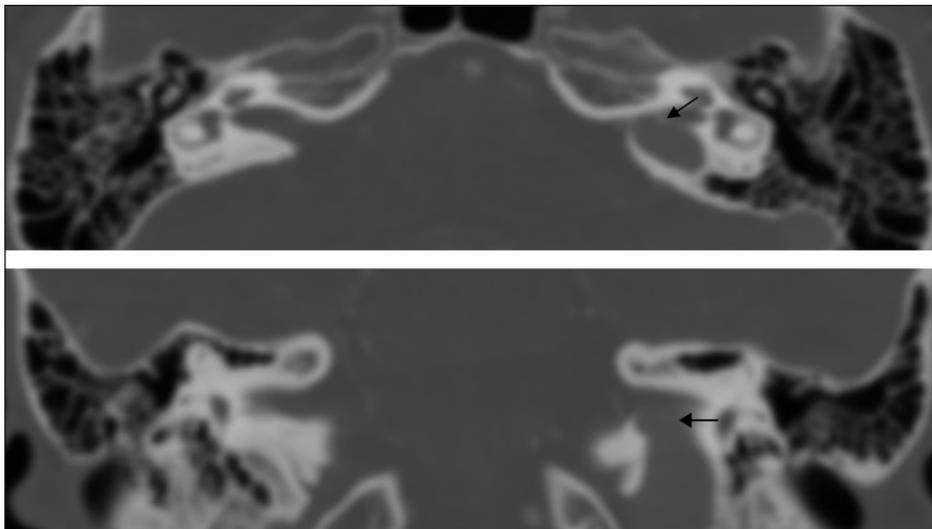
A. Axial temporal bone CT section at level of the internal auditory canal; and B. Coronal temporal bone CT section at level of the internal auditory canal. Note protrusion of the high-riding jugular bulb with a waist-like margin (black arrows)
